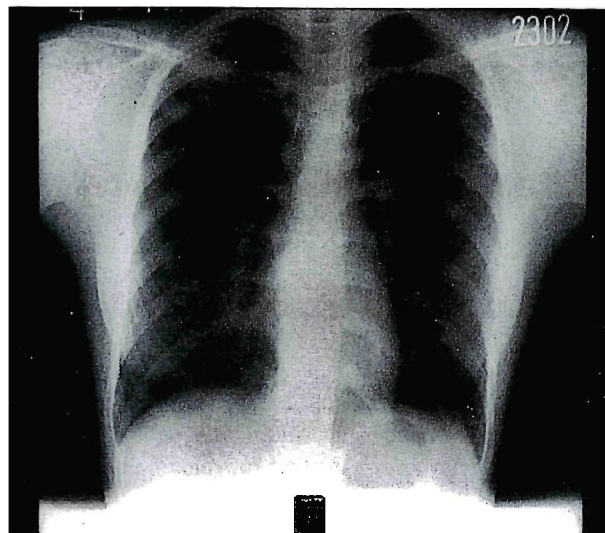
Chest x-ray of Case C (bIII1).
